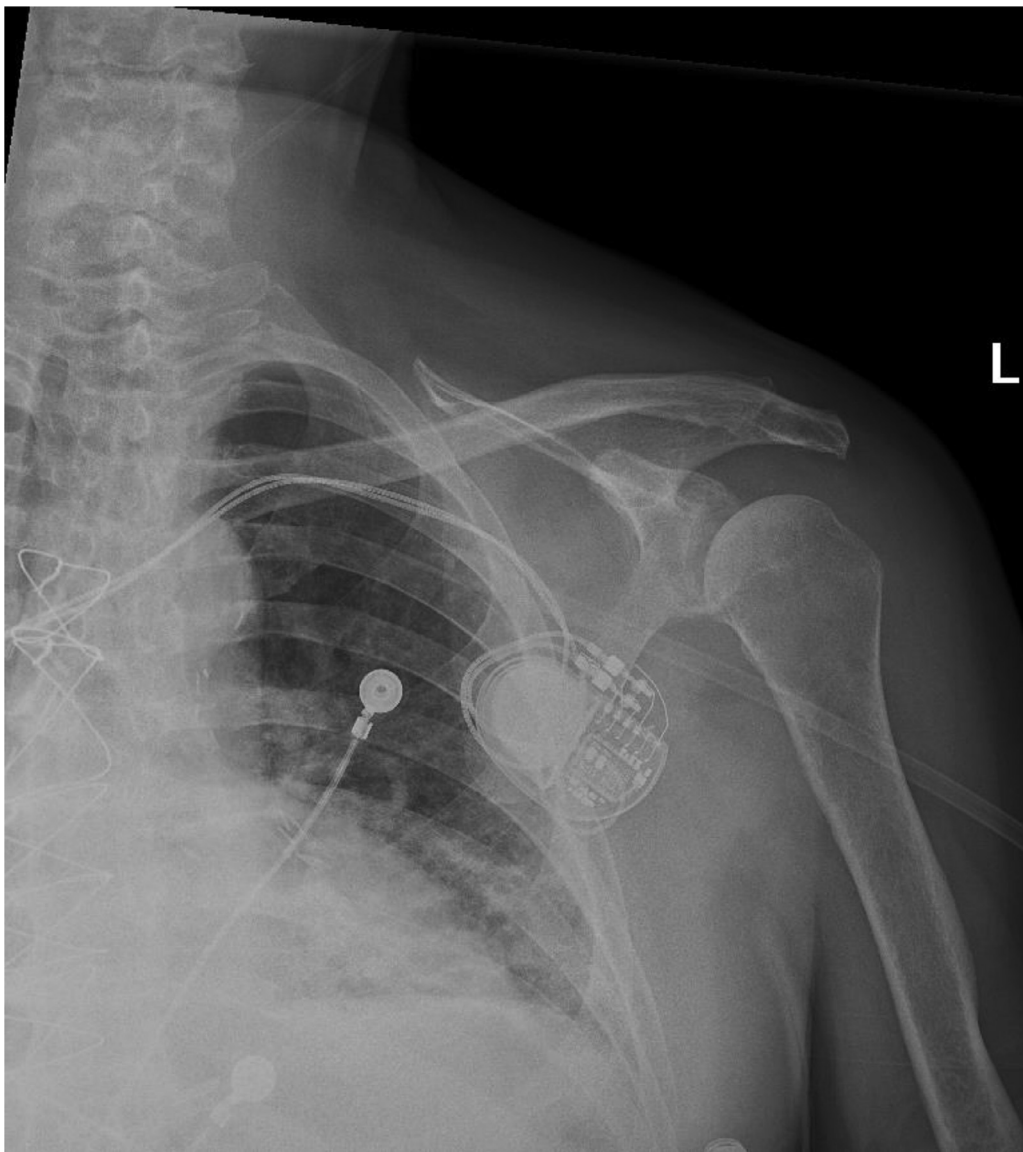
(A) Left shoulder X-ray (anteriolateral view) depicts inferior displacement of the left humeral head on the glenoid fossa (pseudosubluxation) secondary to joint effusion consistent with hemarthrosis. (B) Left shoulder X-ray demonstrating inferior displacement of the left humeral head on the glenoid fossa.
